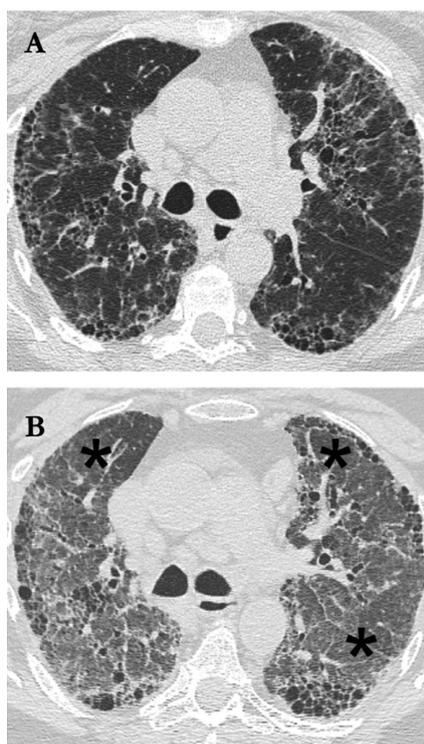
Progressive fibrosing interstitial lung disease. A. Initial chest HRCT shows bilateral, subpleural, subtle interstitial reticulation. B. Chest HRCT performed nearly two years later showed progression of interstitial abnormalities, with peripheral ground-glass areas superimposed to intralobular septal thickening and mild bronchiectasis.
